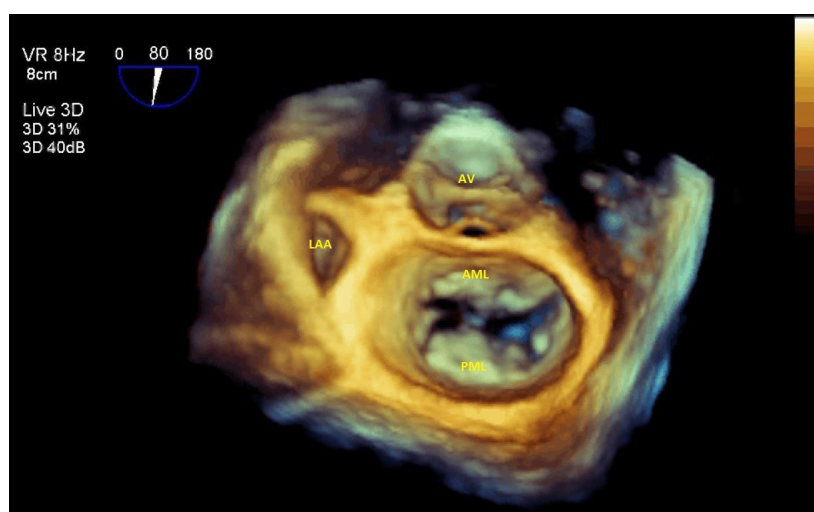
Live/real-time three-dimensional transesophageal echocardiography shows an en face view of the MV. MV: mitral valve; AML: anterior MV leaflet; AV: aortic valve; LAA: left atrial appendage; PML: posterior MV leaflet. Copyright with Aiman Smer
